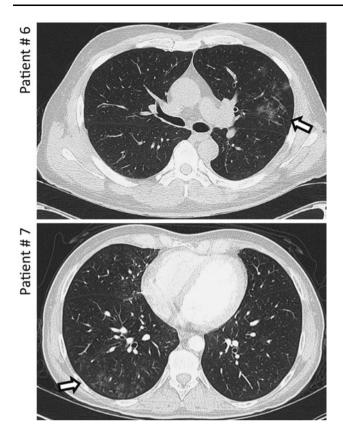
Chest computed tomography (CT) findings at diagnosis. Patients are marked according to the code used in the tables. The *arrows* indicate ground-glass pattern
